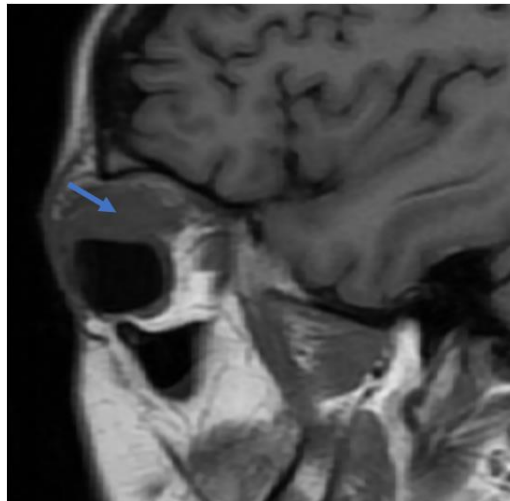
Sagittal T1-weighted MRI showing an isointense orbital mass (blue arrow).
